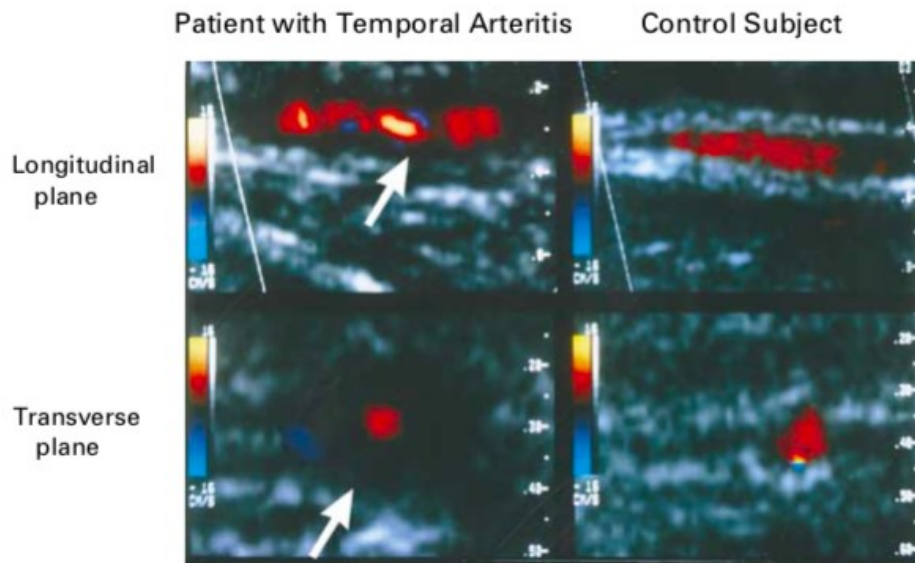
First description of the use of colour-duplex ultrasonography to detect temporal arteritis reported by Schmidt et al. in 1997 (66).
